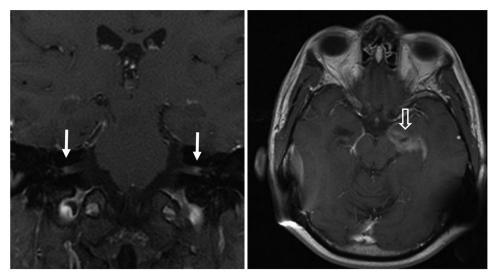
Magnetic resonance imaging: left, coronal TI gadolinium sequence shows enhancing lesions in the distal internal auditory canals (arrows); right, axial TI gadolinium sequence shows an enhancing lesion of the left hippocampus (open arrow).
